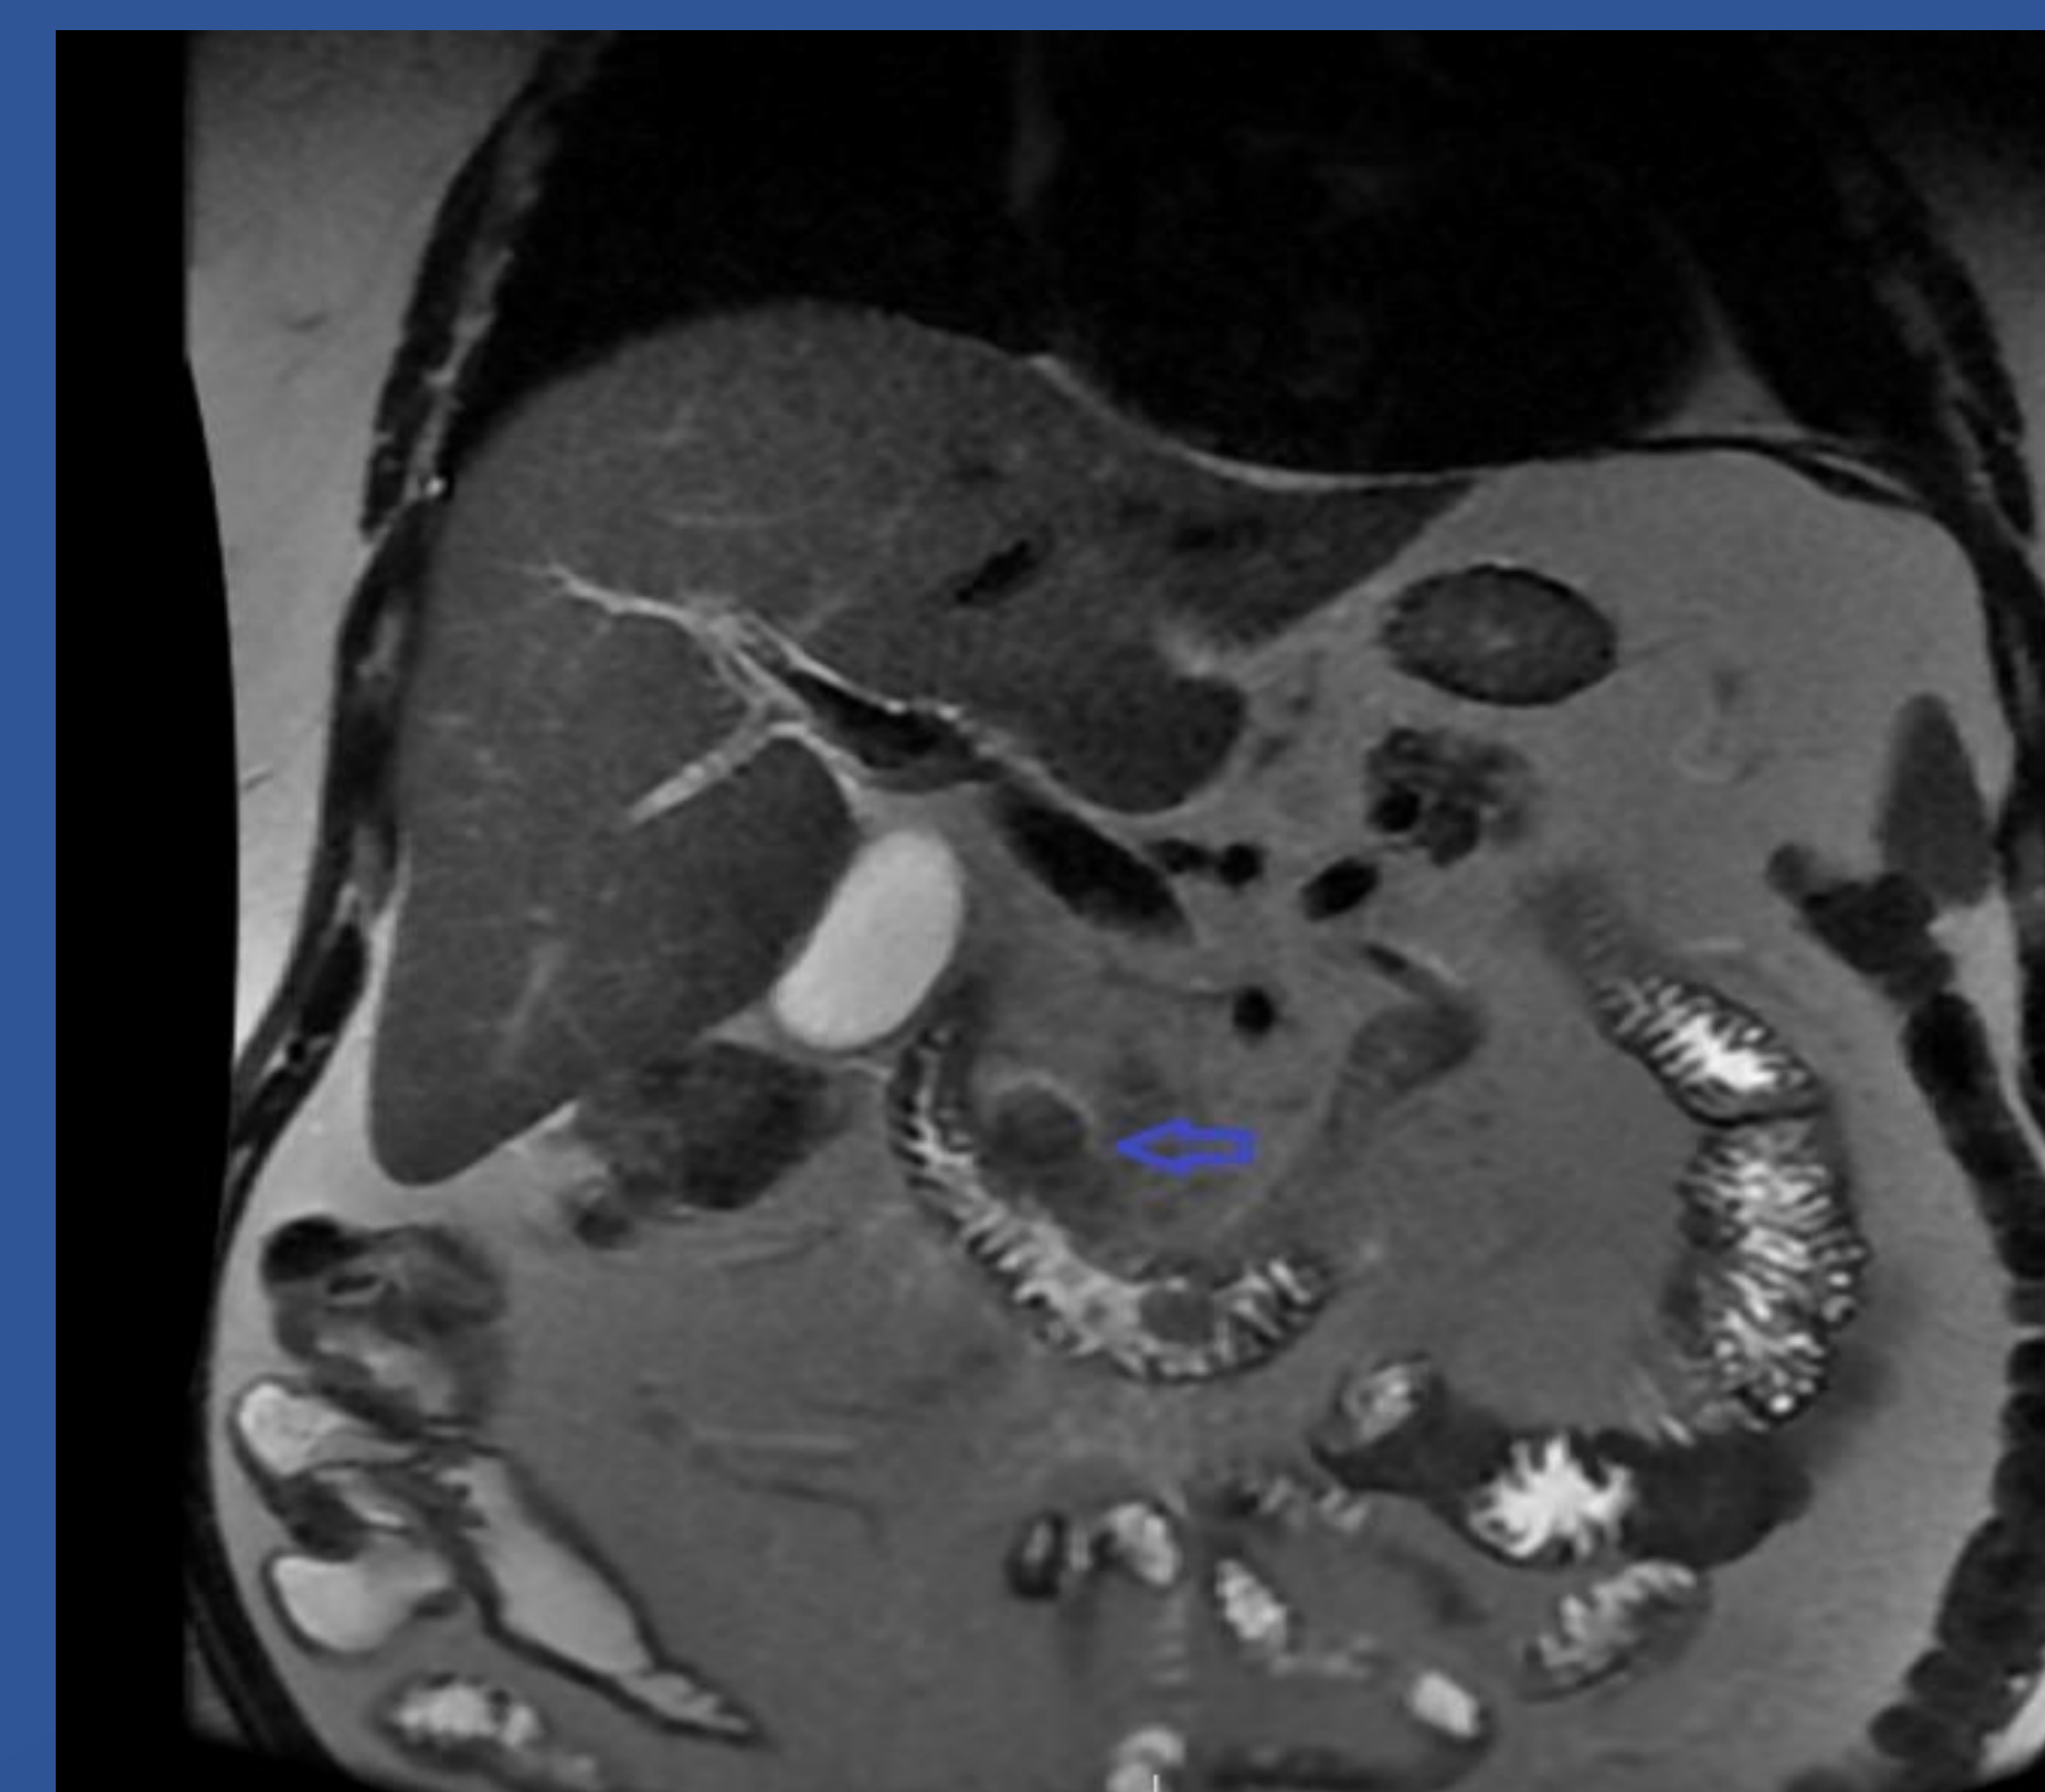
MRI of the abdomen showing significant inflammatory changes adjacent to the proximal duodenum.
